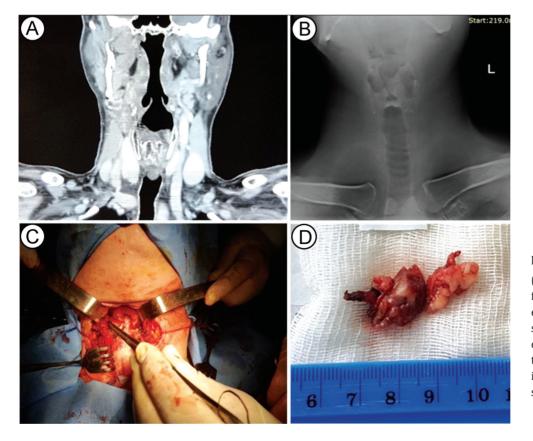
A 57-year-old male with laryngeal cancer included in this study. (A) – CT showed a tumor mass arising from his left vocal cord with local extension to left supra-ligamentous space; (B) – digital tomosynthesis confirmed the findings and ruled out thyroid cartilage involvement; (C) – intraoperative picture; (D) – surgical sample following partial laryngectomy.
